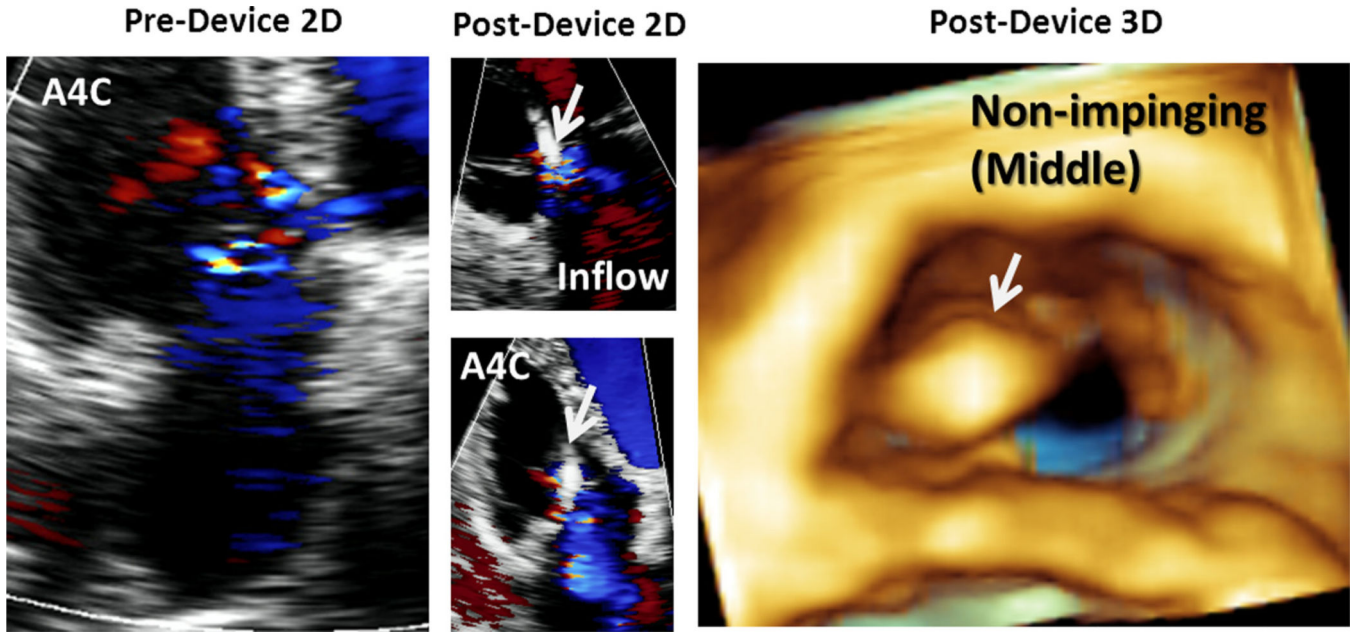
Noninterfering lead. Color flow recordings of the TV with trace TR before device lead placement (*left*) and mild TR after device lead implantation (*middle*). Three-dimensional zoom (*right*) confirms device lead in the central position. *White arrow* points to device lead. *A4C*, Apical four-chamber; *inflow*, RV inflow view. See also Video 4.
